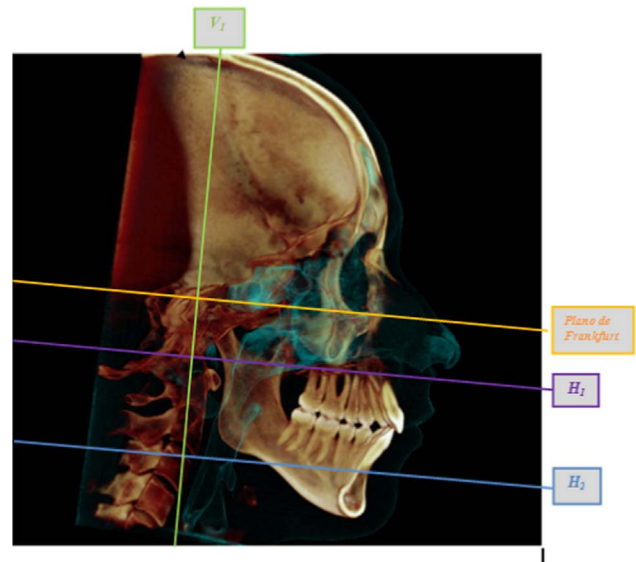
Demarcation of the regions on a CBCT image.
